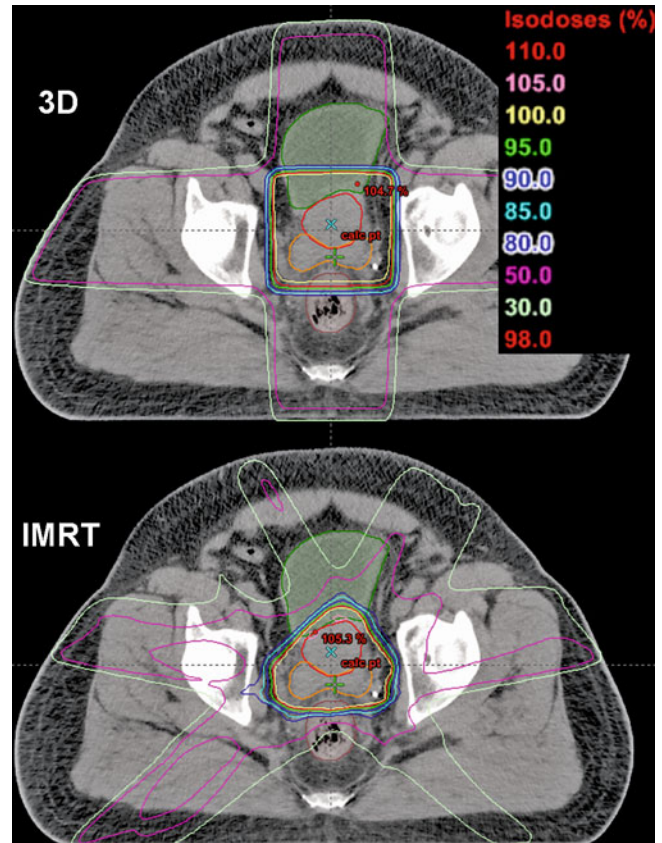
Axial CT slice showing the planned isodose distributions for typical 3D and IMRT radiotherapy to the prostate (*red contour*) and seminal vesicles (*orange contour*). The IMRT plan delivers and achieves better dose sparing of the rectum, bladder, and femoral heads
